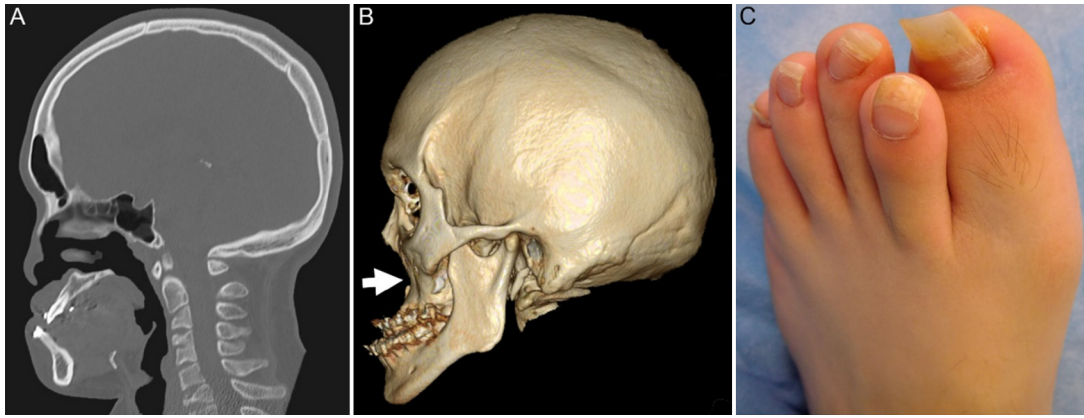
Hypoplasia of facial bone (A: head CT, B: 3D image) and (C) abnormalities of fingers.
